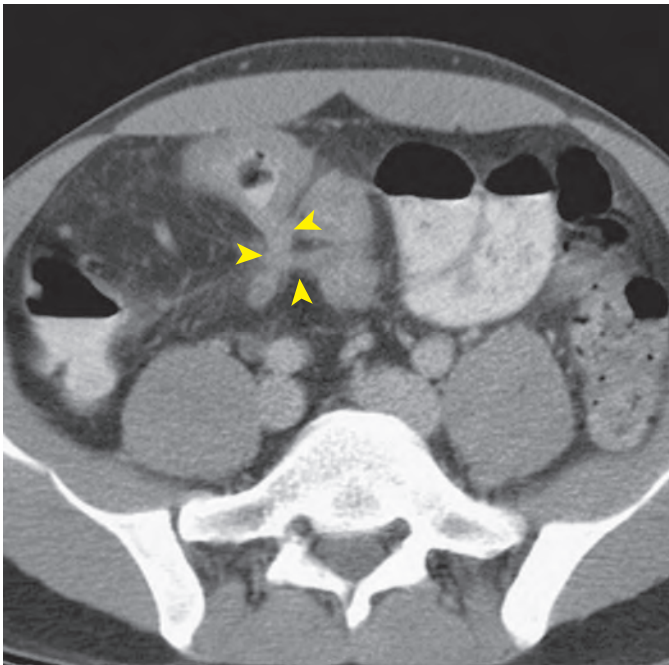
Crohn's disease with enteroenteric fistulas. This enhanced CT scan shows circumferential thickening of ileal loops with multiple linear soft tissue tracts extending between the loops representing interloop (enteroenteric) fistulas (arrowheads). Fibrofatty proliferation is also present in the mesentery.
